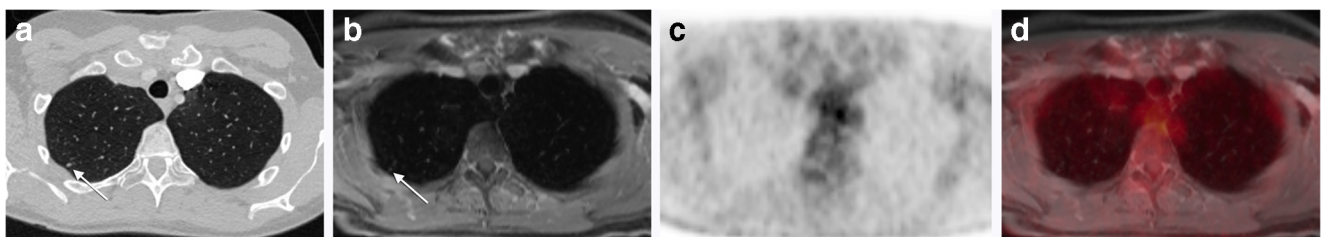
54-year-old man. Axial stand-alone chest CT (A). PET/MR: corresponding level axial contrast-enhanced VIBE (B), corresponding axial PET (C), and fused PET/MR image (D). A 6-mm nodule in the right
